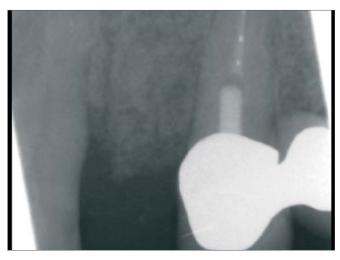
to 23: Clinical and radiographic situation three months postoperatively shows an excellent implantological horizontal and keratinised alveolar ridge profile in region 22, vertical resorption as expected of 2.5 millimetres mesial and 1 millimetre distal to the defect, which will (partially) improve following implant prosthetic restoration.
